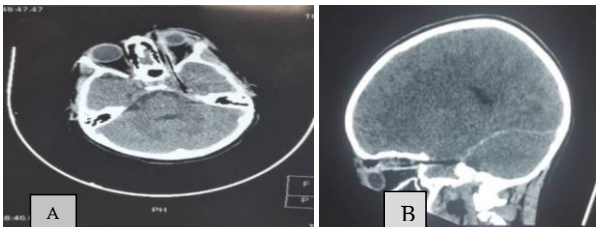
CT scan(A) axial and (B) sagittal views showing the hypodense linear-shaped wooden foreign body.
